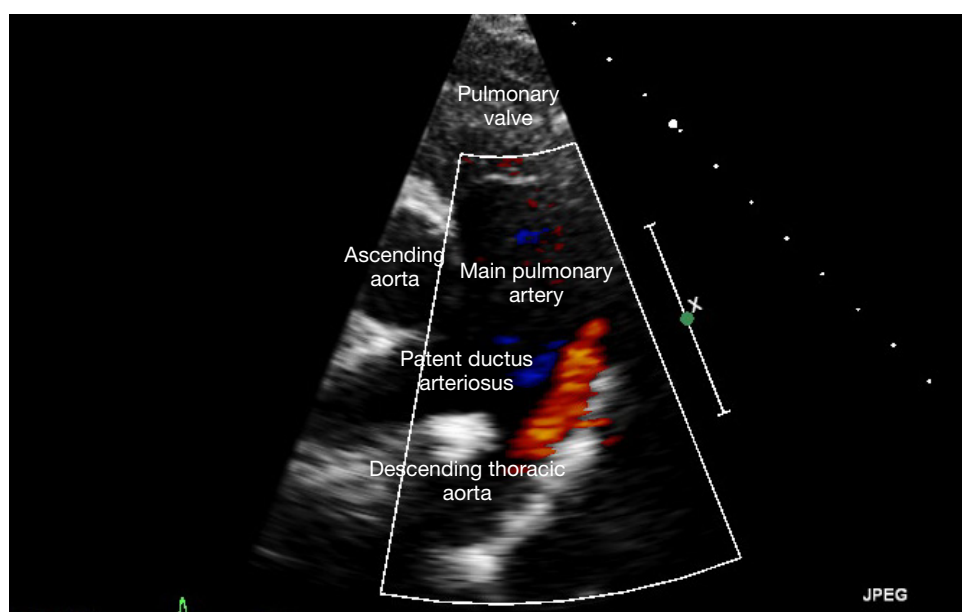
A two-dimensional transthoracic echocardiogram (modified parasternal short-axis right ventricular outflow tract view) with colour compare showing widely patent ductus arteriosus along with pulmonary valve, with Doppler colour flow (red) demonstrating aortic to main pulmonary artery shunt (left to right).
